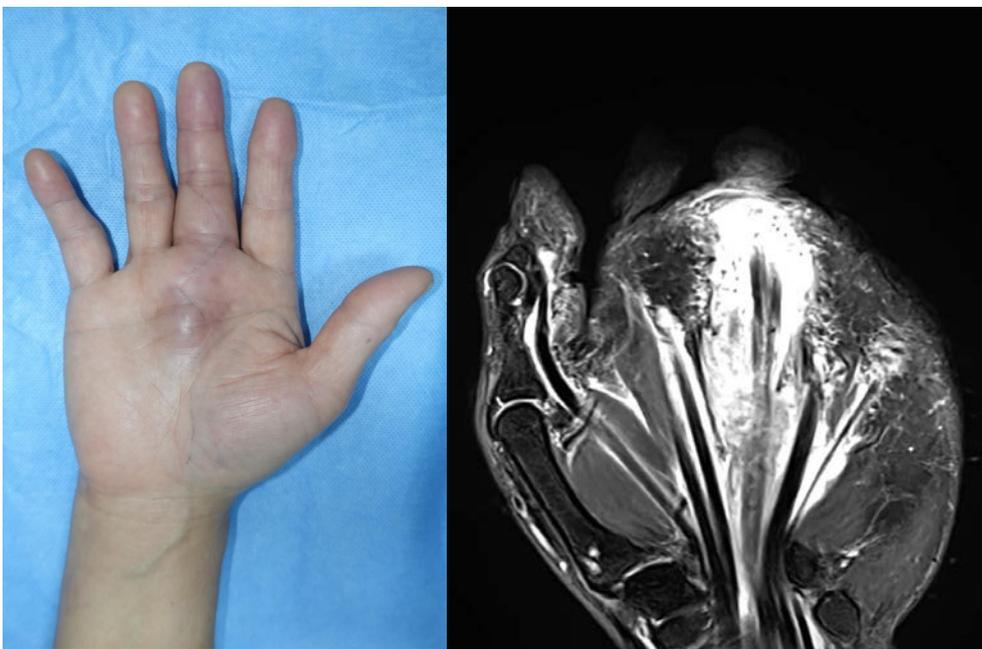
Swelling over midpalmar are of Rt long finger and previous operation scars. Pre-operative magnetic resonance imaging shows prominent tenosynovial thickening and fluid collections(Red arrow).
